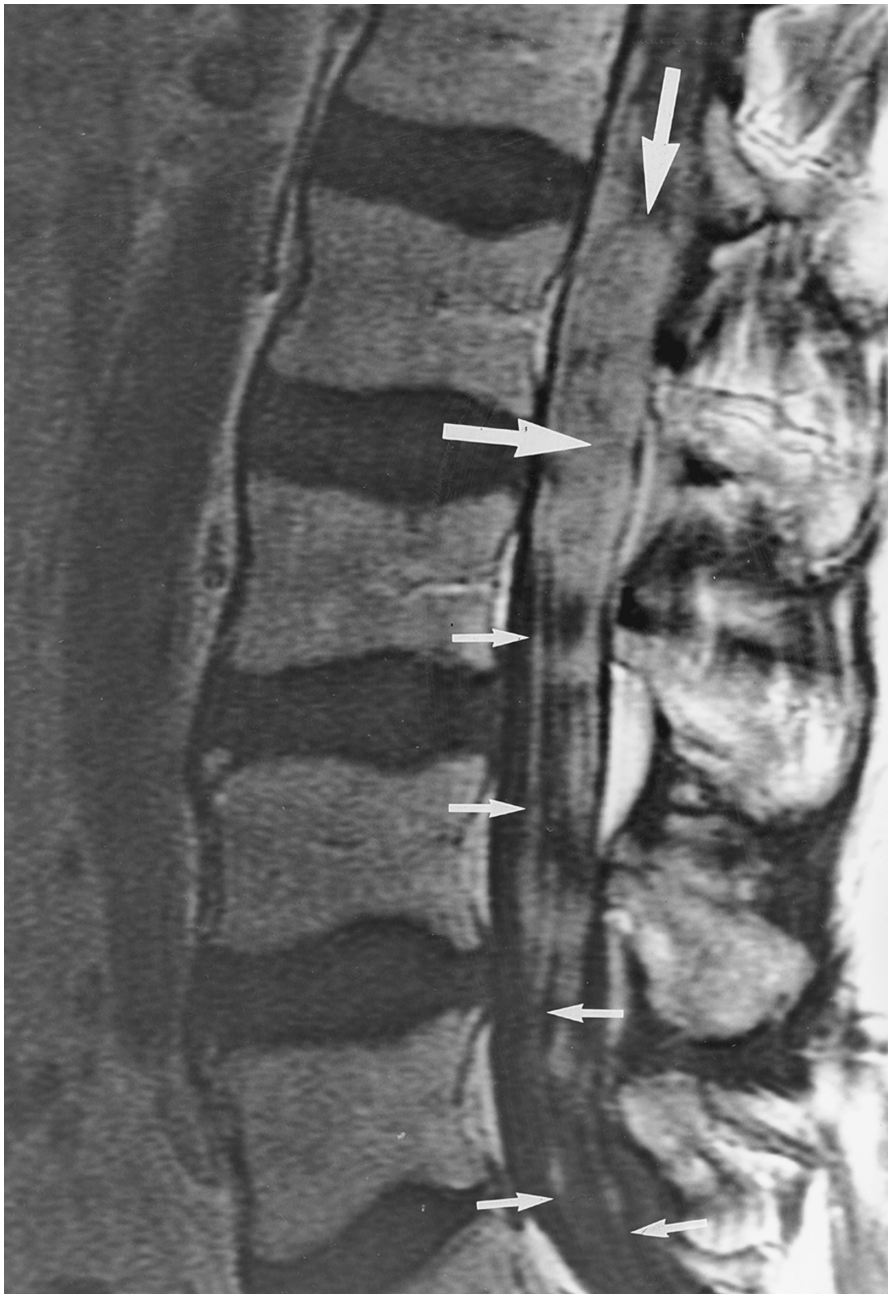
Melanoma with leptomeningeal metastatic tumor infiltration of the lumbar nerve roots. Post-contrast sagittal MRI scan shows that the lumbar subarachnoid space is filled with metastatic tumor (arrows). Lumbar nerve roots are markedly thickened with nodular enhancement (small arrows), indicating tumor infiltration.
